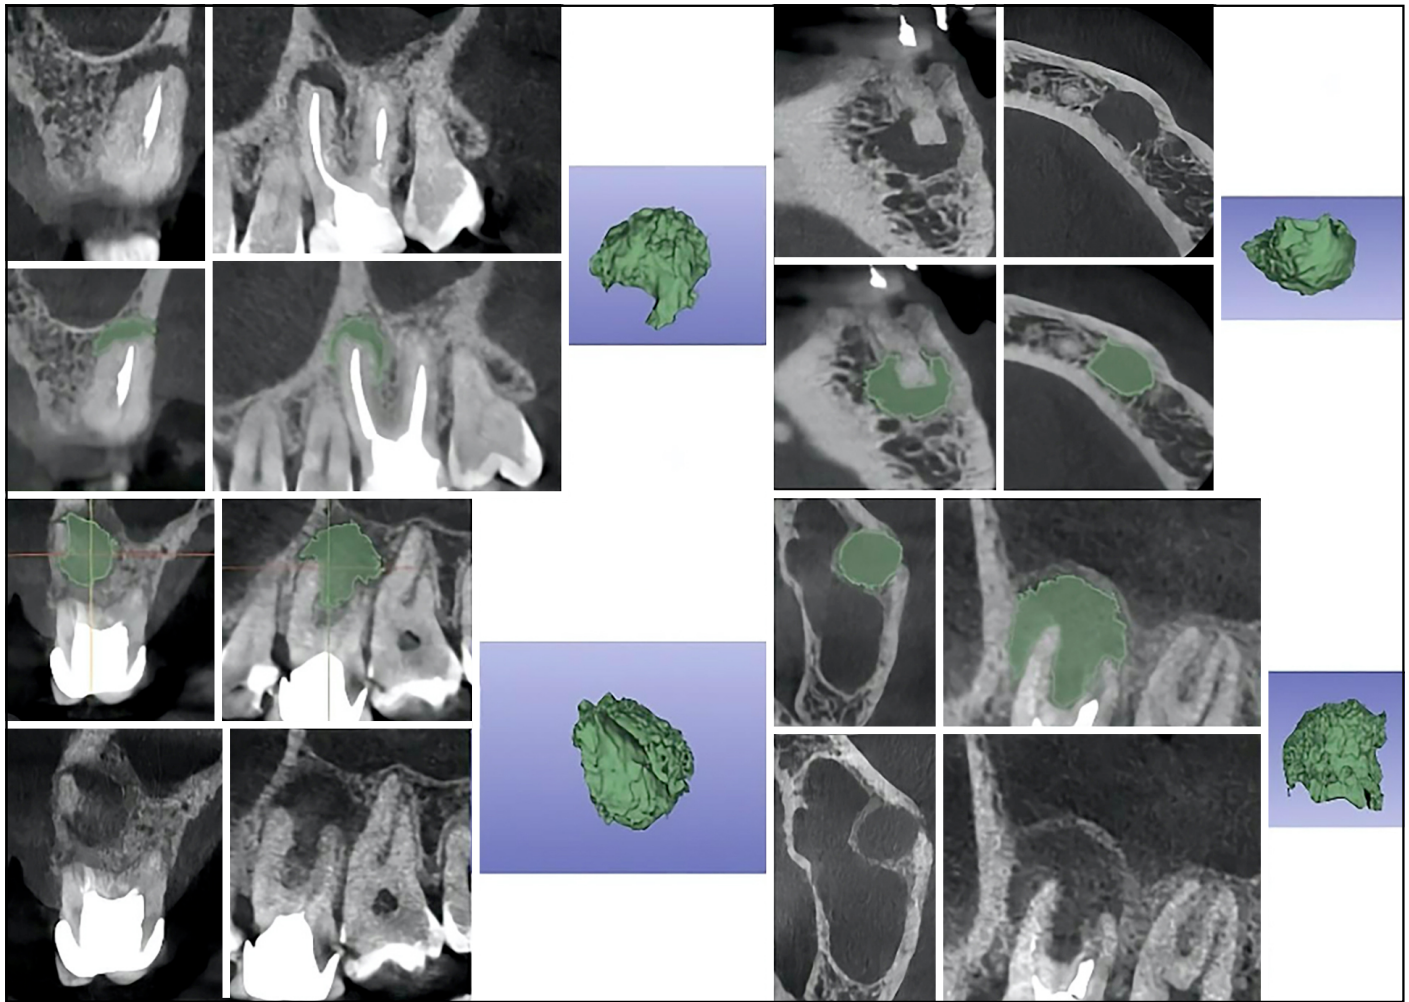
Pre- and post-segmentation imaging of periapical lesions utilising 3D Slicer software is demonstrated. The upper multiplanar reconstruction images reveal a CBCT scan with periapical lesions before segmentation. The lower multiplanar reconstruction images exhibit the lesions post-segmentation process (outlined in green). The image on the right shows a 3D reconstruction, accentuating the lesion's detailed topography
